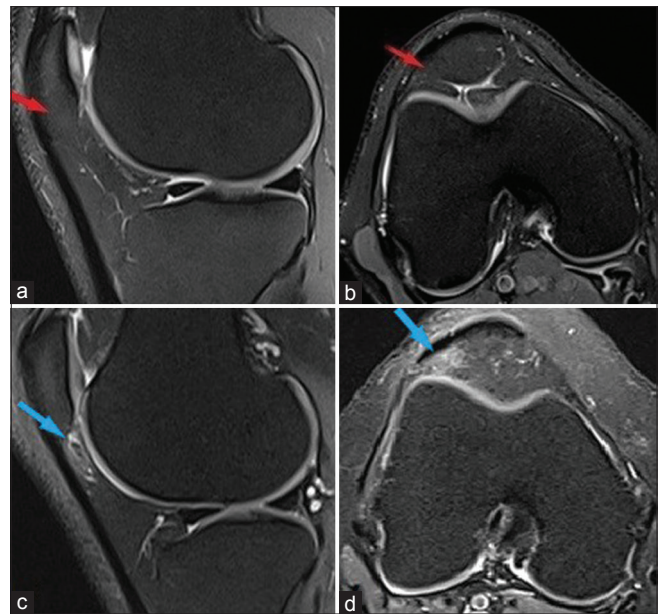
Sagittal (a and c) and axial (b and d) magnetic resonance images showing superolateral Hoffa's fat pad. a and b show normal fat signal (red arrows) in this area. In another patient's knee, there is increased signal (blue arrows) consistent with edema (c and d)
